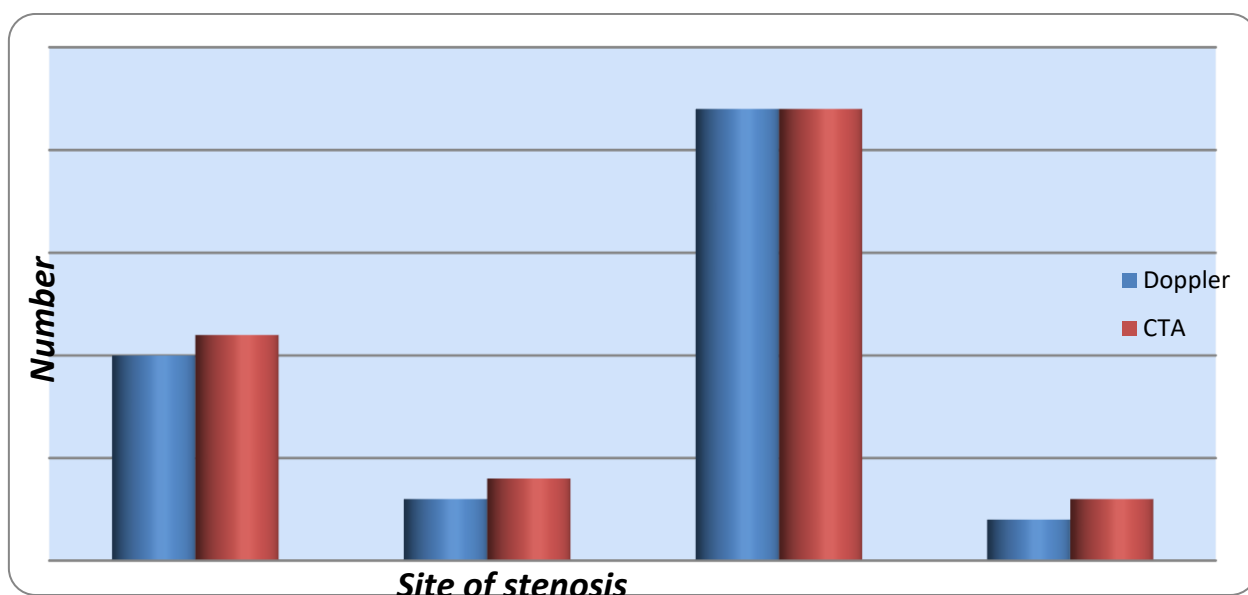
Comparison between CTA and Doppler in detecting site of stenosis
